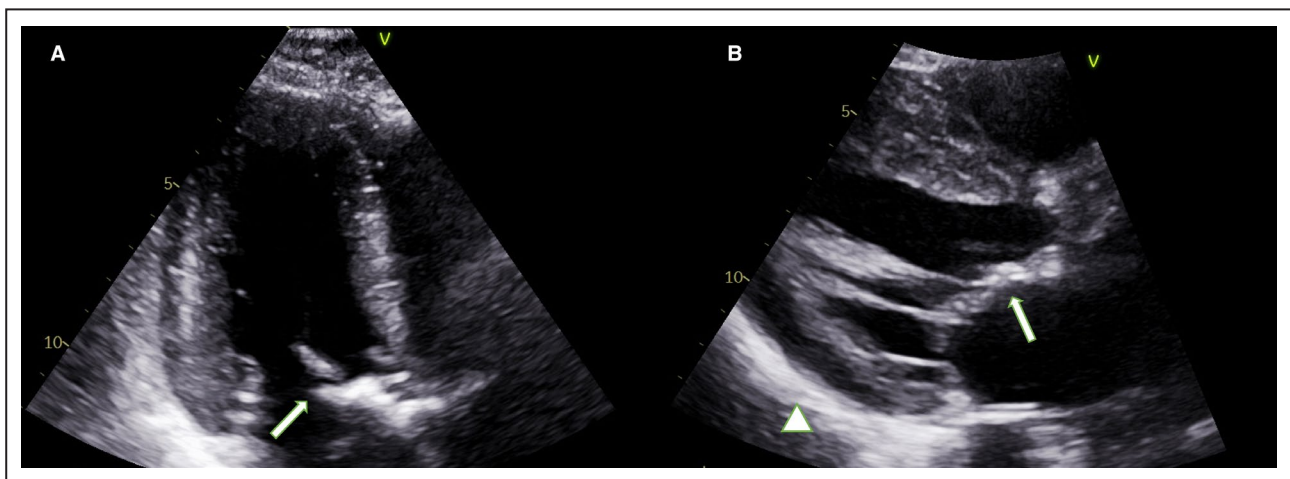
Echocardiographic findings of radiation-induced heart disease.
